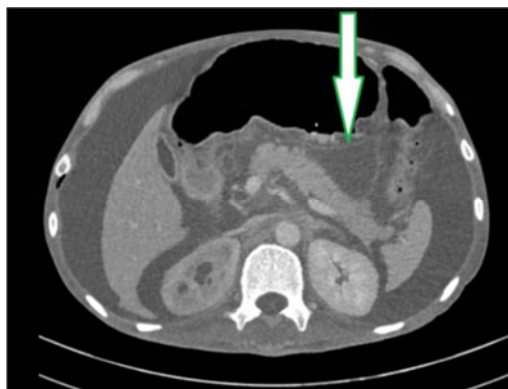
Repeated CT abdomen imaging shows larger peripancreatic fluid collection measuring 3.3cm X 3.7cm X 2.8cm (AP X W X CC) with concomitant ascites.
